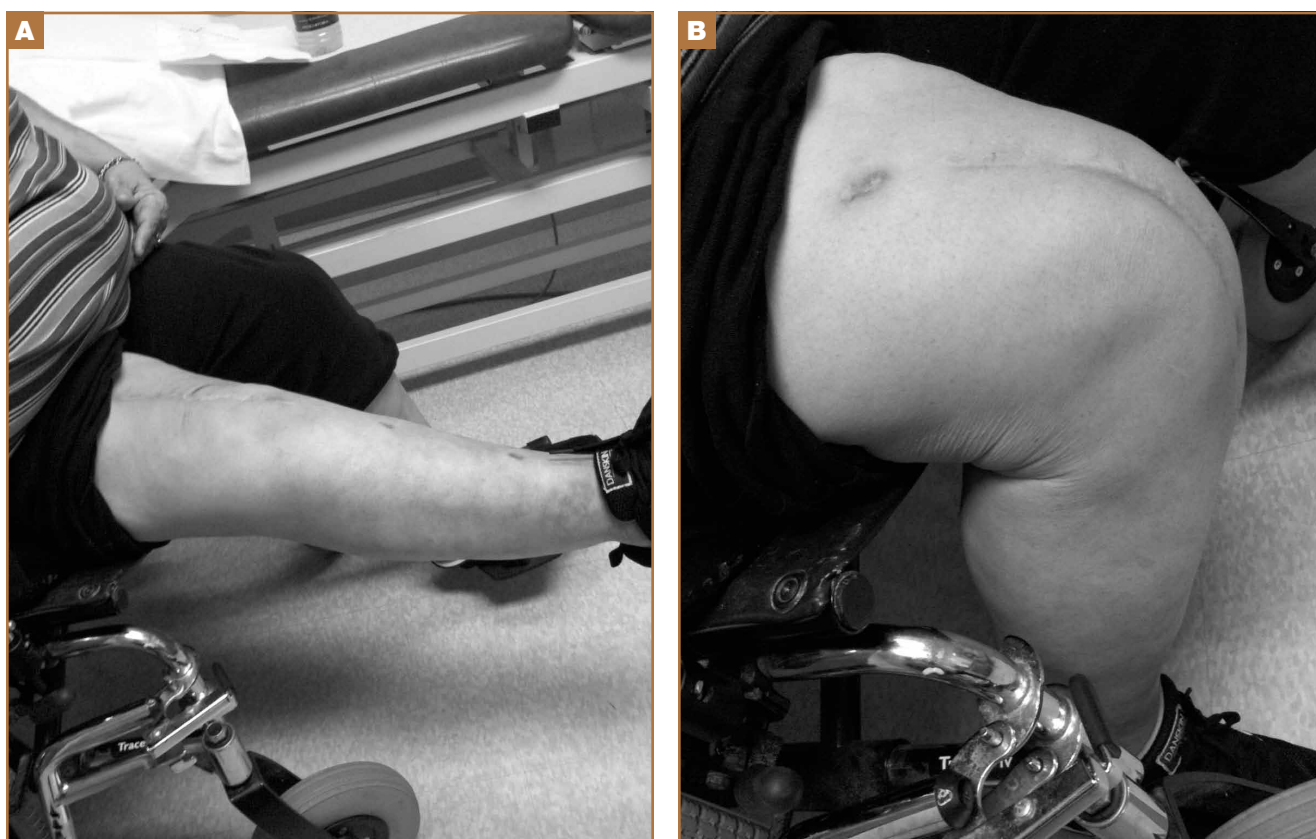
Clinical radiograph 6 months after surgery shows (A) 10° extensor lag and (B) 120° of active flexion of knee.
